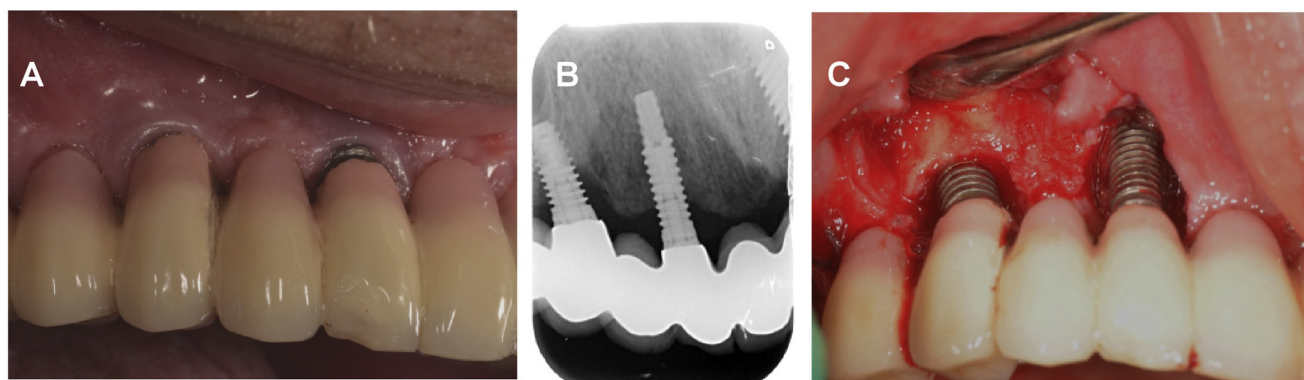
Peri-implantitis. A. Clinical view. B. Periapical radiography showing low osseous density around the mesial implant, and peri-implant bone loss involving 50% of the distal implant length. C. View of the osseous defects after surgical debridement.
